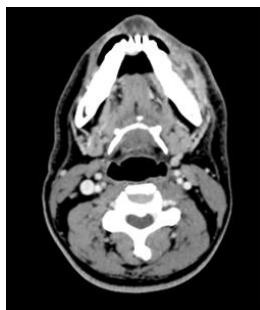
Contrast enhanced CT scan (Axial section) in a 54-year old male with SCC of Buccal mucosa demonstrates an enhancing soft-tissue mass involving the Left buccal space.
